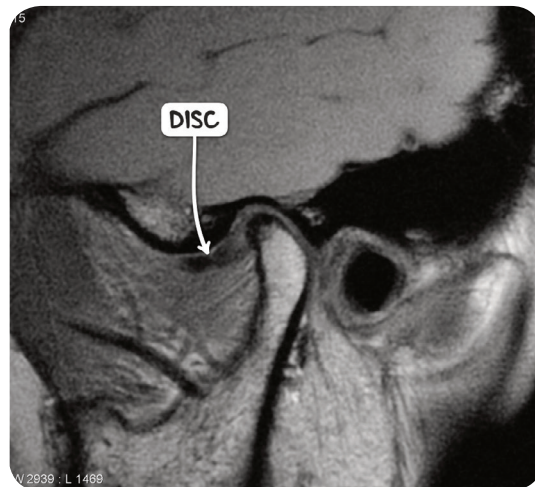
An MRI scan of the head in the parasagittal plane demonstrating an anteriorly dislocated disc in an individual reporting symptoms of temporomandibular joint dysfunction.
